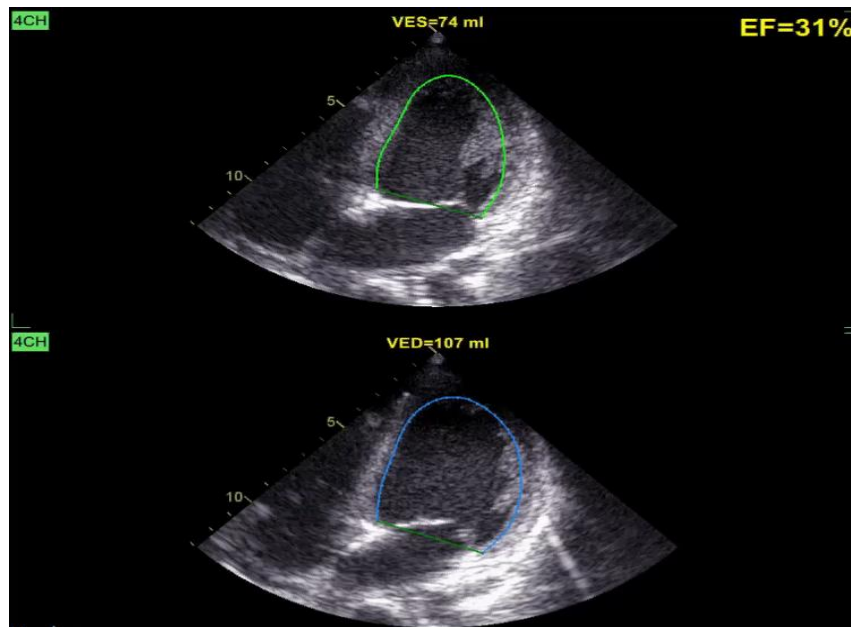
Transthoracic Echocardiogram showing decreased left ventricular systolic function
